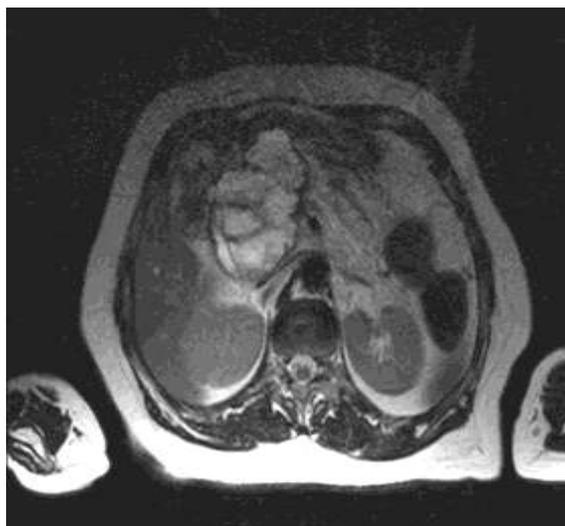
CE MRI of upper abdomen: Aksial plane: Pancreas head and neck neoplasm with local infiltration of adjacent blood vessel and infiltration in duodenum. Cystic component.
